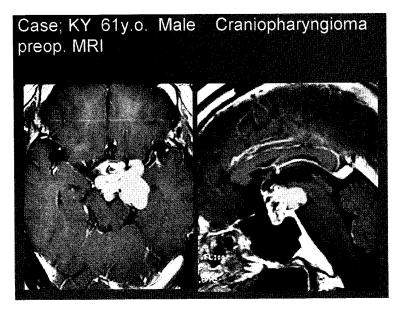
Preoperative MRI of representative case
